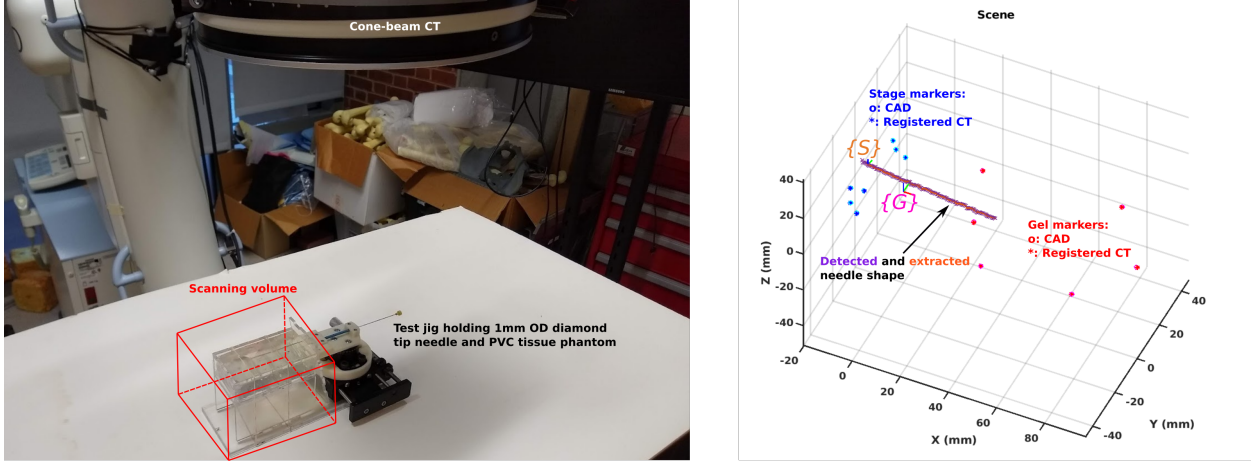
Image registration and motion detection with CT.
